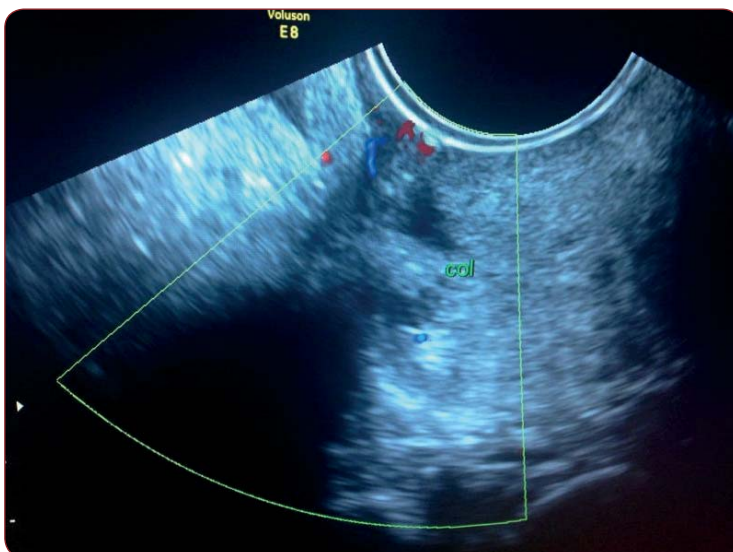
Echographic aspect of the cervix – note the vascularization of the tumor during color flow Doppler.
